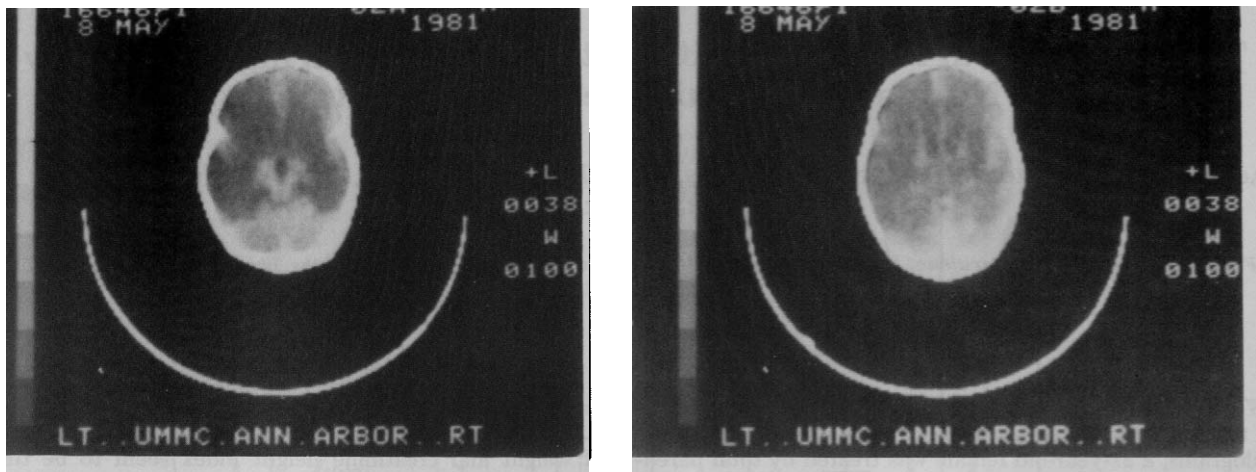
CT scan showing loss of cerebral cortex and resultant ventriculomegaly.
